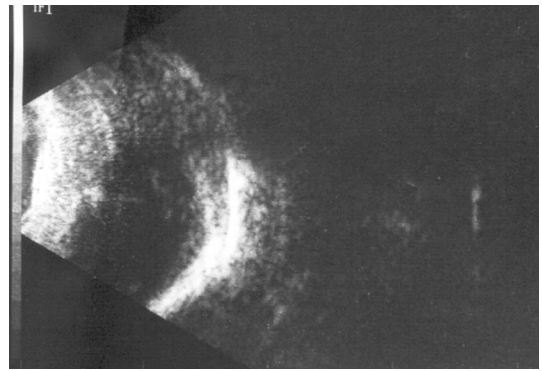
B scan ultrasound of a gel polyethylene sphere 90 days after surgery
